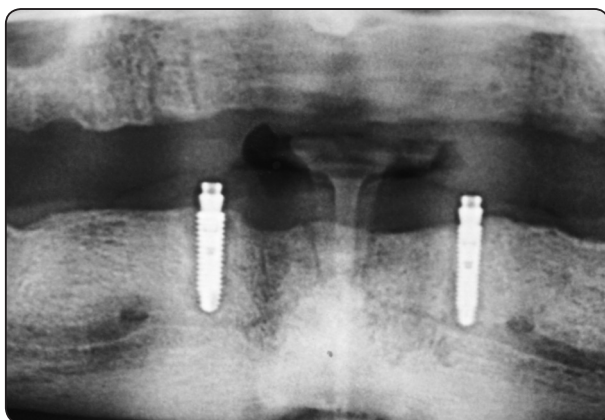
A radiograph of the two implants with equator attachments inserted in the mandibular edentulous arch.
